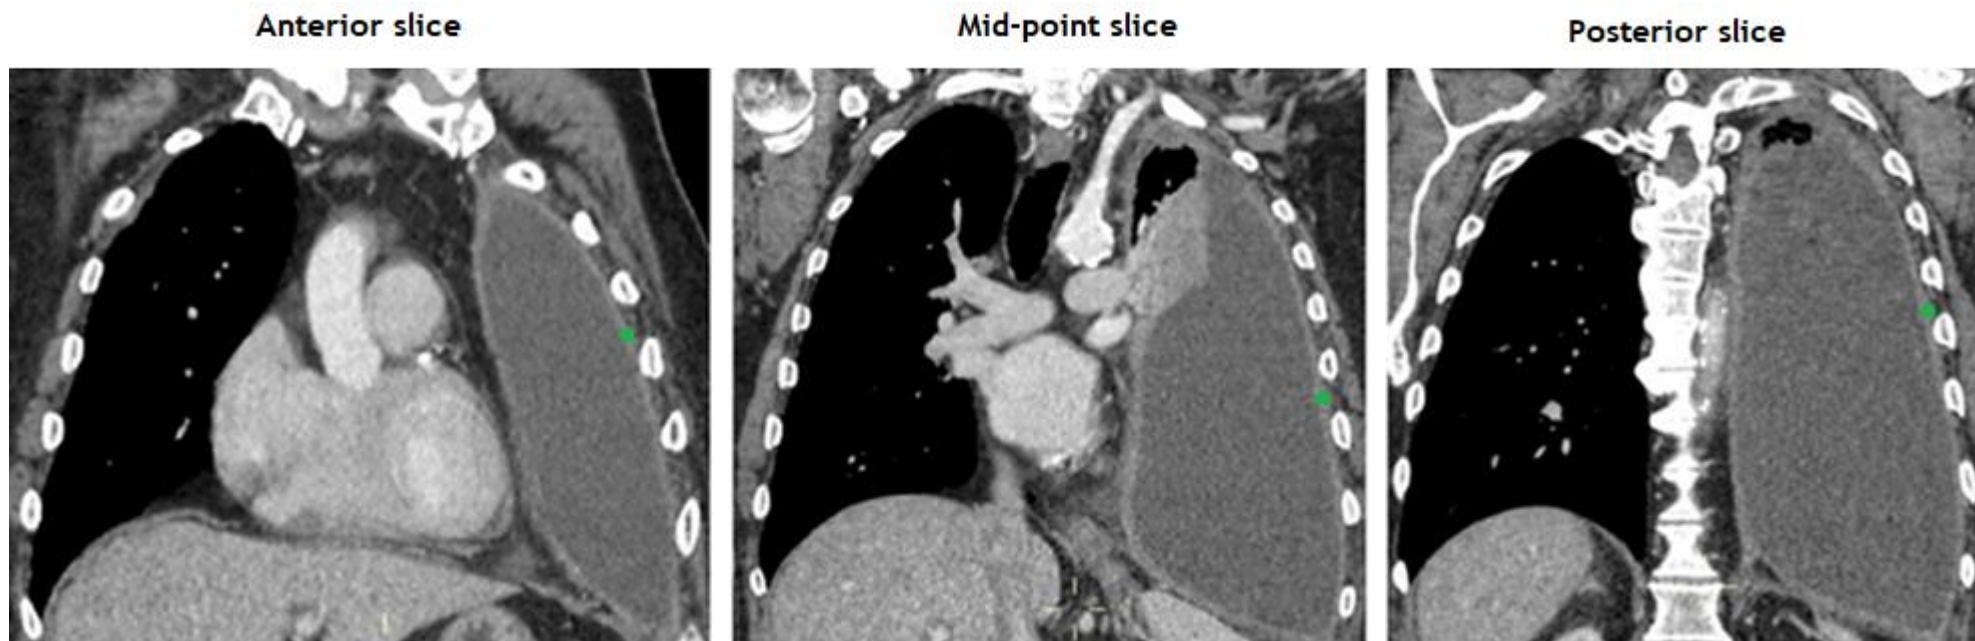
Coronal plane of contrast-enhanced CT scans with ROIs placed on areas representative of pleural tumour across three different slices (highlighted by the green dots)
